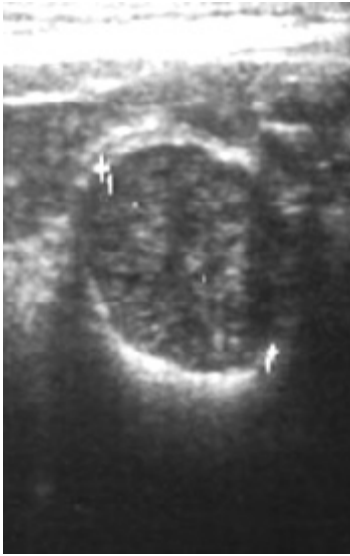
Colonic polyp appearance in conventional sonography
